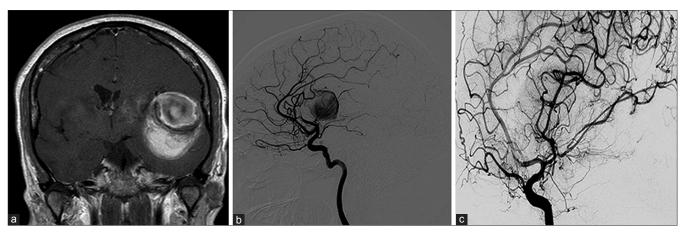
(a) Preoperative MRI,TIw sequences with gadolinium injection: Aneurysm mass located in the left Sylvian fissure, (b) Preoperative angiography showing the aneurysm's injection from a branch of the middle cerebral artery, (c) Postoperative angiography showing the complete exclusion of the aneurysm from the circle
